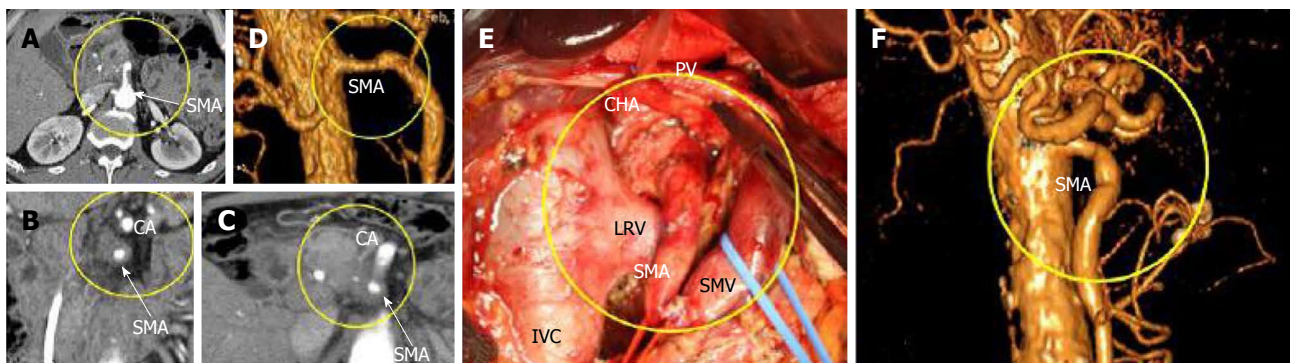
In this 59-year-old man (case 4), 360° pancreatic ductal adenocarcinoma encasement of the superior mesenteric artery was diagnosed on computed tomography (A-D), while endoUS data described only tumor abutment with the superior mesenteric artery. A-C: Computed tomography (CT), Arterial phase, Axial images. CT showed circumferential infiltration of the SMV. The CA was intact; D: CTA. Local narrowing of the SMA at the site at which it was circumscribed by the tumor; E: Intraoperative photograph. An extended Whipple procedure was performed. There were no signs of SMA involvement during surgery. The level of resection was R1 because of the contact of the SMA with the tumor; F: CT angiography. Three months postsurgery. No relapse and no narrowing of the SMA. SMA: Superior mesenteric artery; SMV: Superior mesenteric; PV: Portal; IVC: Inferior caval; LRV: Left renal veins; CA: Celiac artery.
